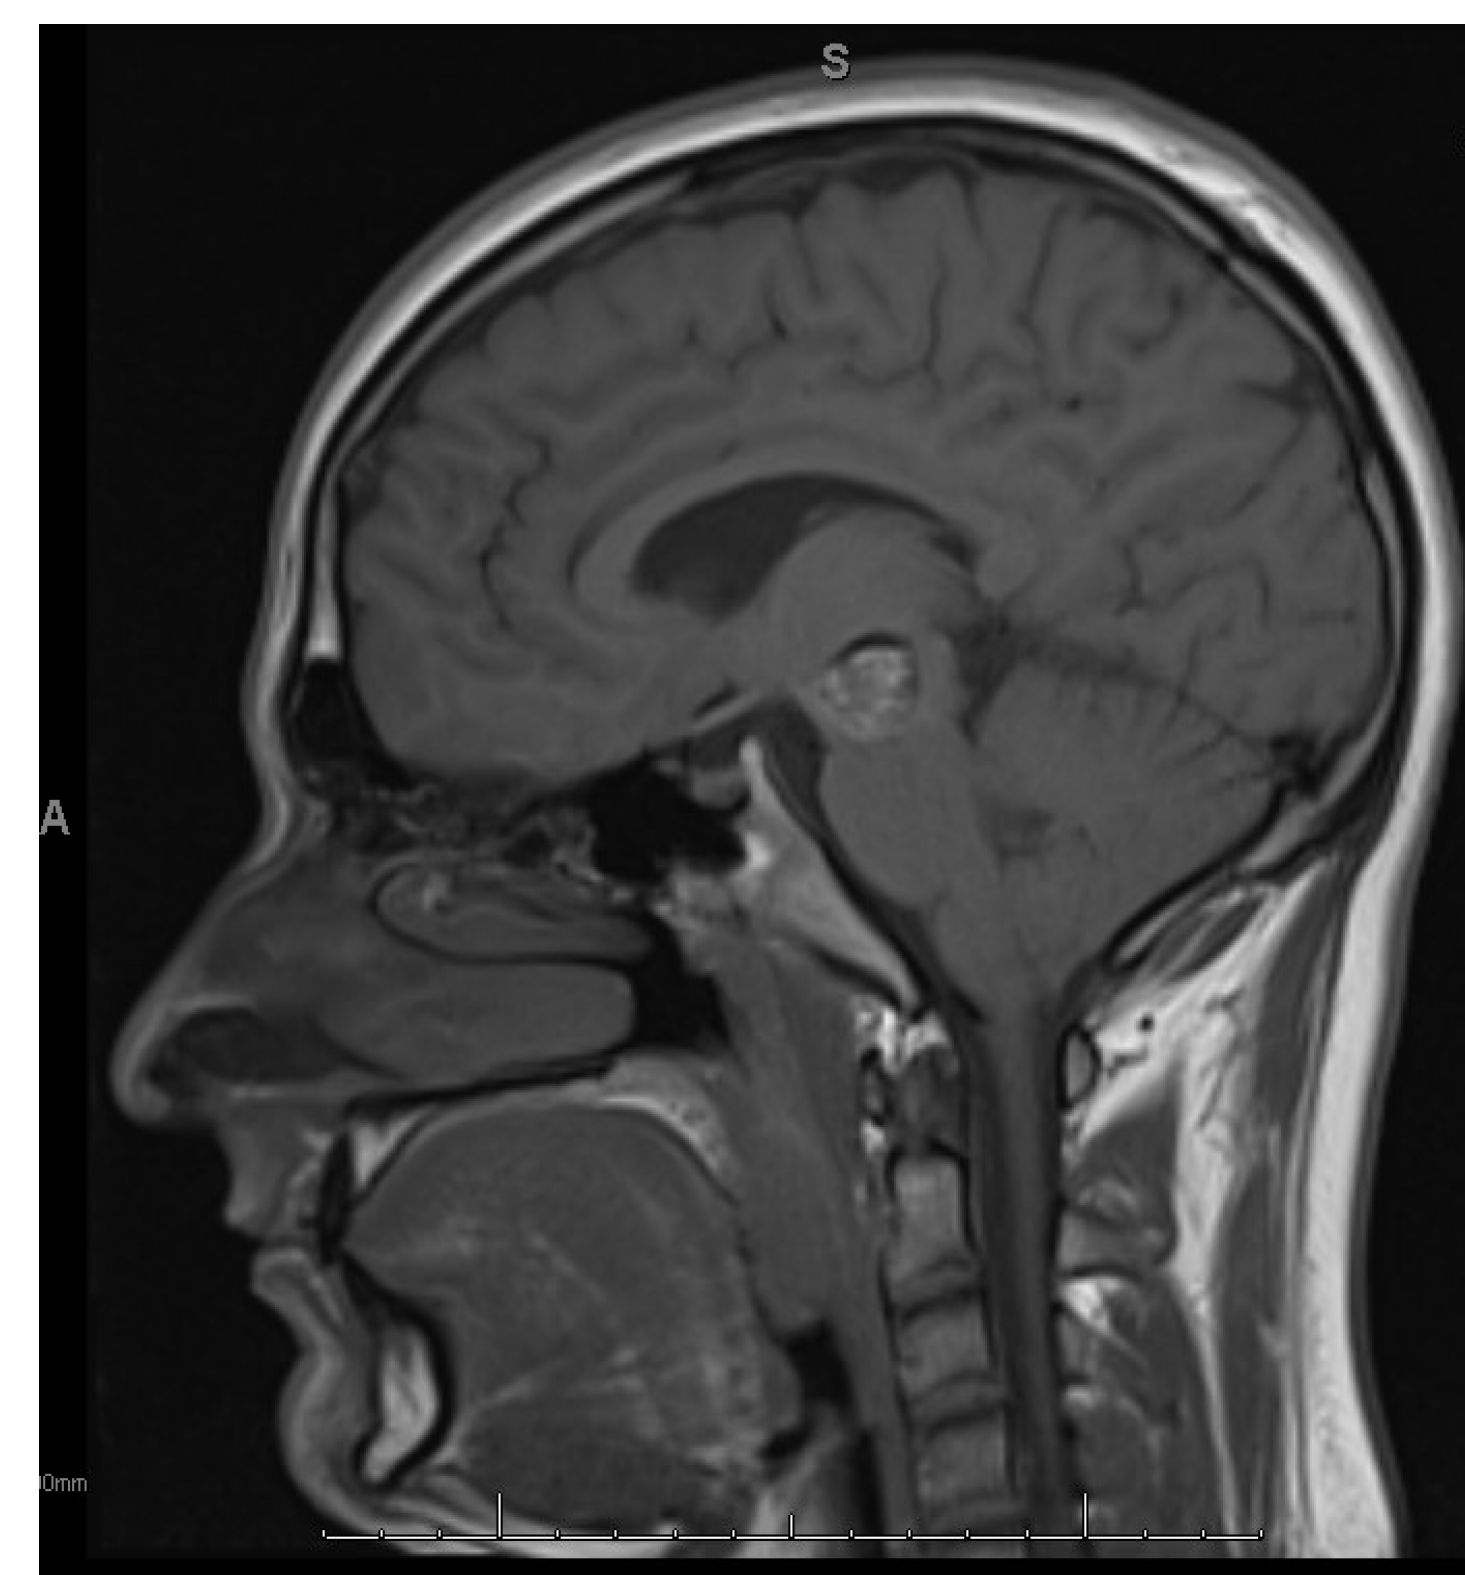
Sagittal view of MRI revealing cavernous angioma of R cerebral peduncle.
